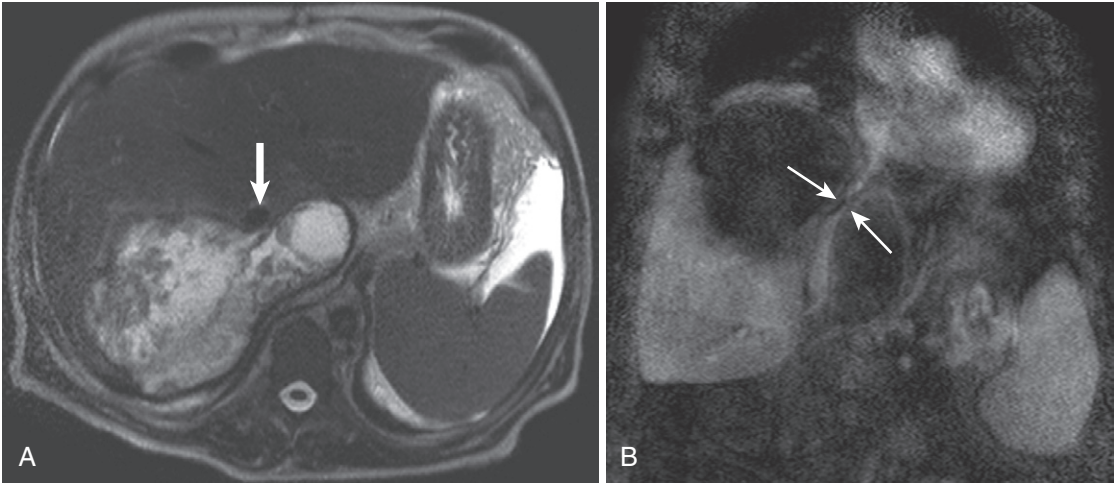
Inferior vena cava (IVC) stenosis. A large complex posttransplant fluid collection abuts the IVC (*arrow* in A) on the T2-weighted image (A) and encircles and narrows the IVC (*arrows* in B) on the coronal enhanced image (B). C, The axial enhanced image corroborates the IVC stenosis (*arrow*).
